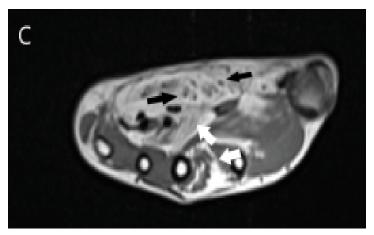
Magnetic resonance imaging of the right hand, T1-weighted sequence in axial section fatty infiltration of muscles (white arrows) and nerve bundles of the median nerve (black arrows) which are also hypertrophied.
